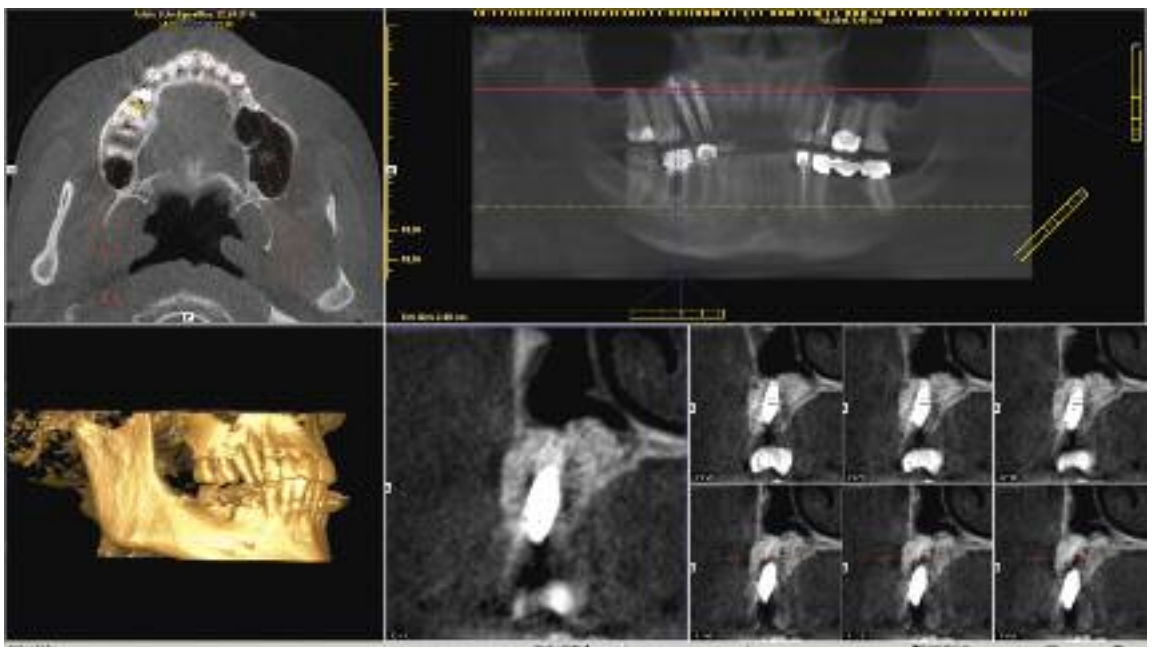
The CBCT image shows very good ossification of the augmentation material after four months.
